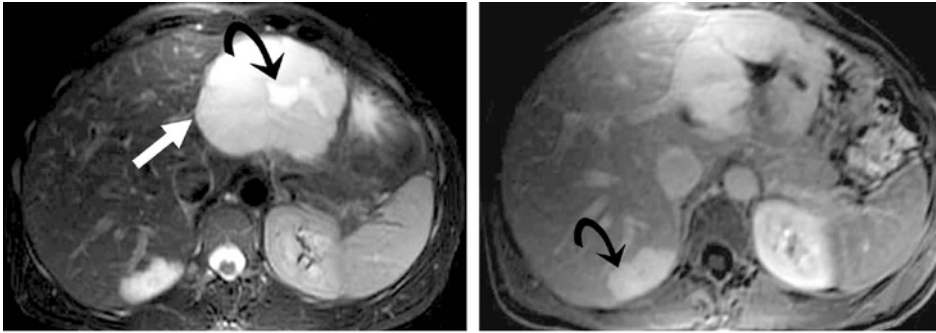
MR imaging of a giant hemangioma with a prominent central scar. a. Axial fat-saturated T2-weighted fast SE image shows a high-signal-intensity giant hemangioma (straight arrow) with a prominent central scar (curved arrow), which has even higher signal intensity than the lesion. Note the smaller hemangioma without a central scar. b. On an axial gadolinium-enhanced fat-saturated 3D GRE image obtained during the delayed phase, the smaller lesion (arrow) has completely filled in, whereas the central scar within the larger lesion has not enhanced.
